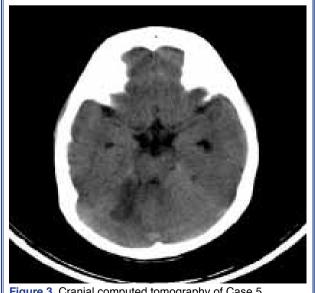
Cranial computed tomography of Case 5.
